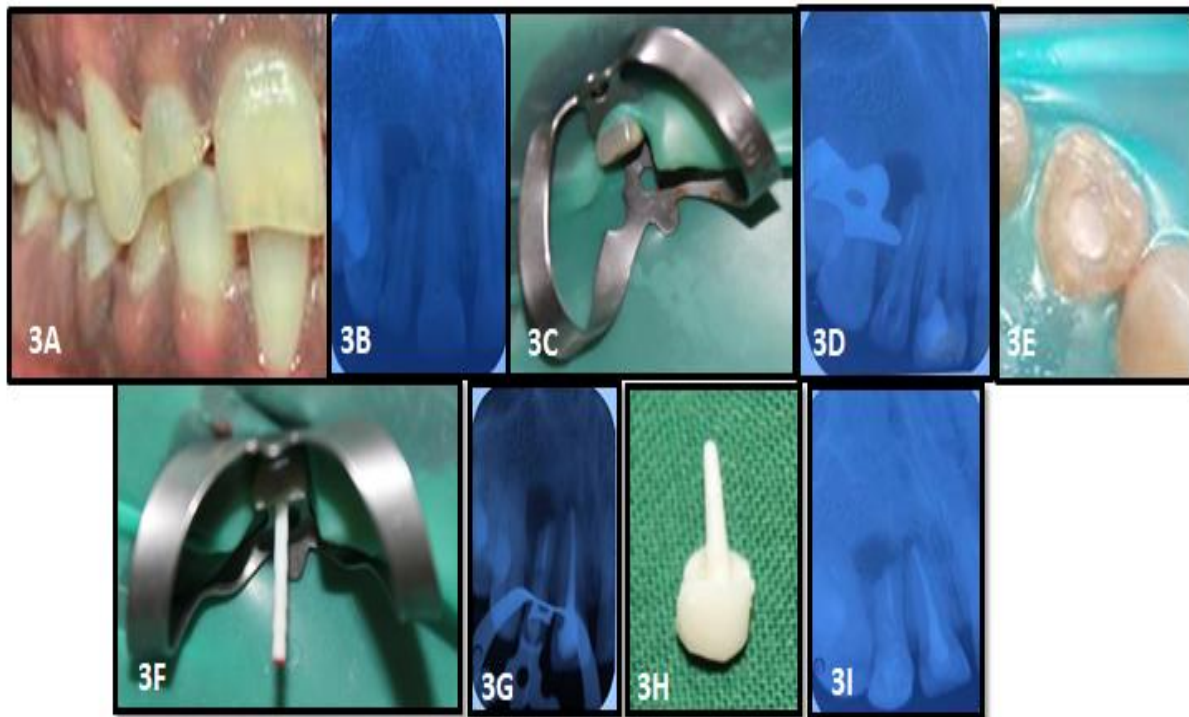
Pre-operative clinical photograph (3A), Pre-operative diagnostic radiograph (3B), rubber dam isolation in 12 (3C), Radiograph showing 3mm MTA plug (3D), Temporary coronal seal established with IRM (3E), Clinical photograph of size 2 fiber post (3F), Radiograph view showing the fit of the post (3G), Aesthetic anatomic post and core assembly after extra oral curing (3H), Radiographic view after post cementation. (3I)
